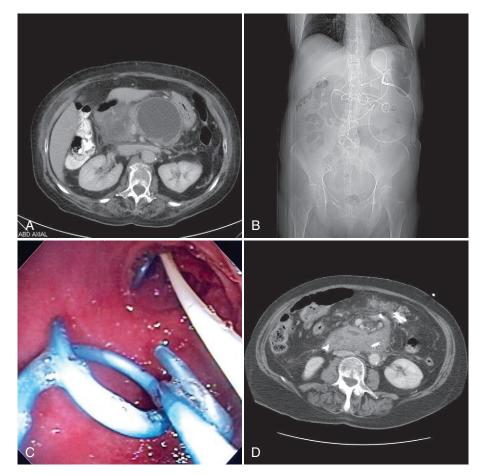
A, Computed tomography (CT) of the abdomen revealing multiple pancreatic fluid collections (PFCs) in this patient. B, Five transmural stents draining three large PFCs are evident on this scout image obtained at CT. One stent is transduodenal, three are transgastric, and one is transesophageal. C, The corresponding endoscopic image of multiple transgastric stents. D, CT of the abdomen revealing complete resolution of all PFCs at 6-week follow-up.
